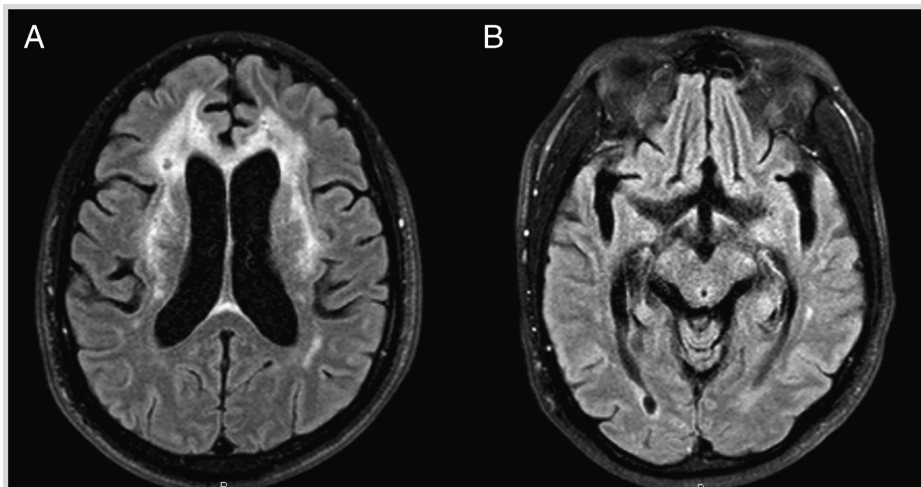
Fluid-attenuated inversion recovery sequence of MRI shows hydrocephalus ex vacuo, diffuse leukoencephalopathy (A), and diffuse, generalized atrophy (B). This degree of leukoencephalopathy is not a cardinal imaging feature of HIV encephalopathy but is commonly found in patients with advanced HIV infection and likely represents axonal injury.
